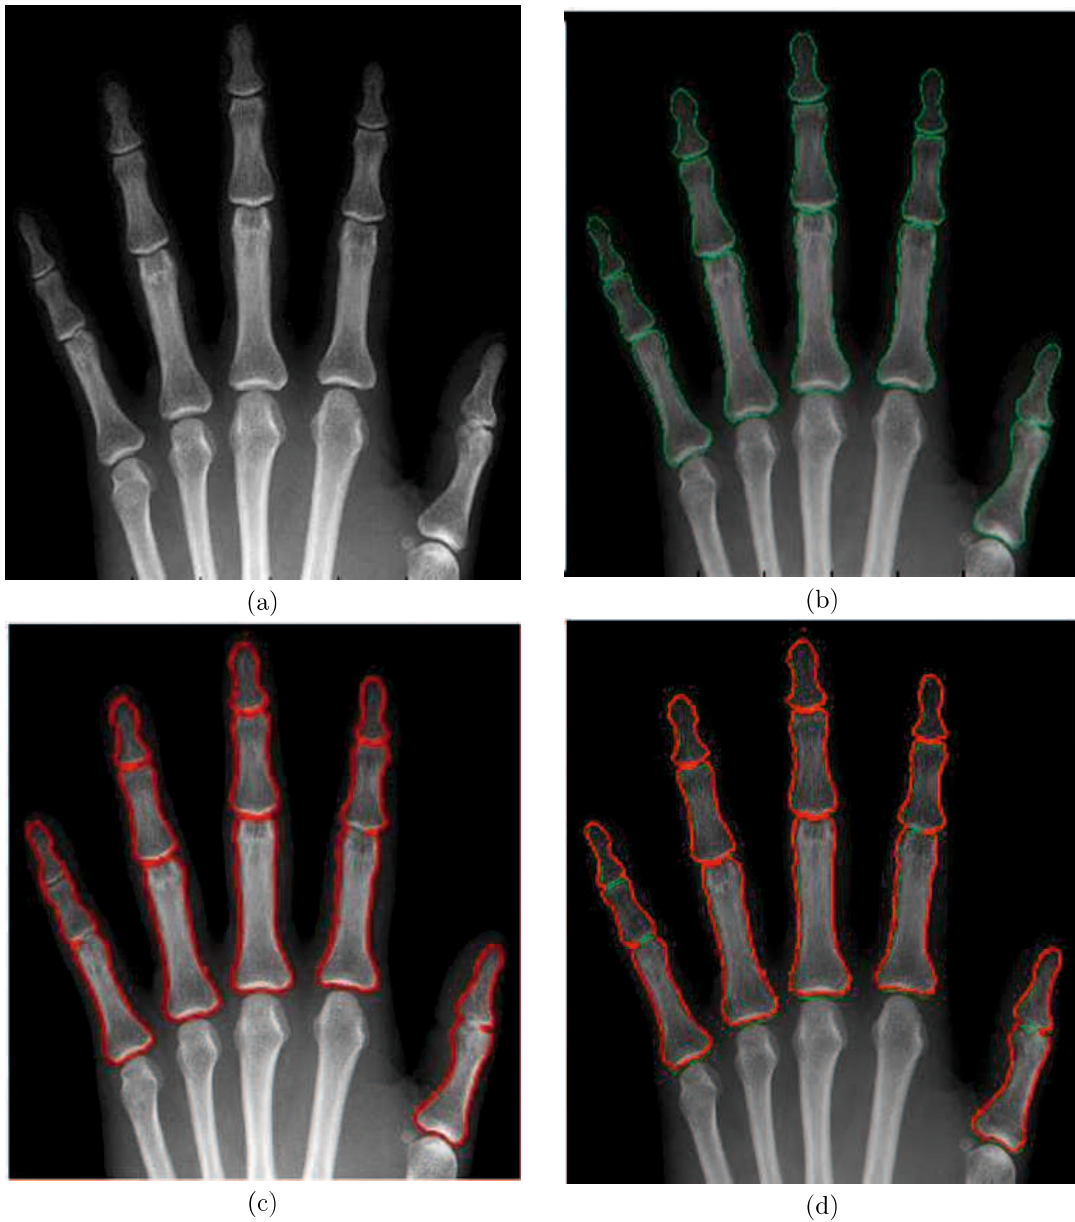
The bone boundary detection results for the left hand radiograph. (a) The left hand bone radiograph to be processed. (b)-(d) The red lines and the green lines show the boundaries detected by the proposed method and those manually detected by an experienced medical doctor, respectively.
